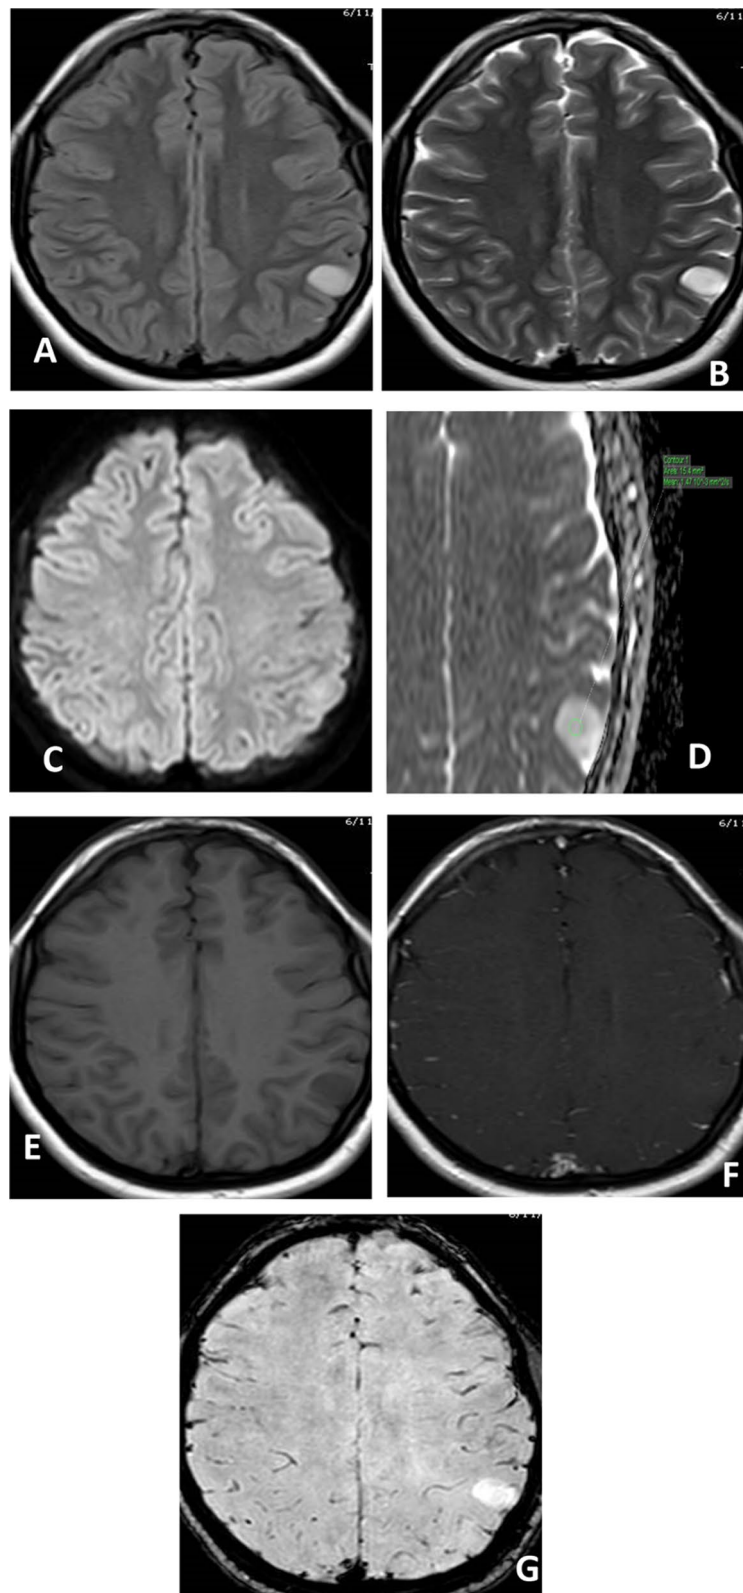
A 12-year-old female child with left parietal low-grade glioma. A Axial FLAIR and B T2WI show high signal left parietal cortical space-occupying lesion. C Axial DWI and D ADC show no diffusion restriction with high ADC value measuring $1.47 \times 10^{-3} \text{ mm}^2/\text{s}$. E Axial pre-contrast T1WI shows low signal. F Axial post-contrast T1WI shows no enhancement. G SWI shows absent hypointense signal foci (ITSS score 0)
